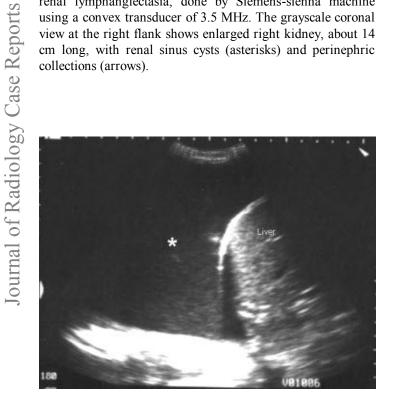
Abdomen ultrasound of a 22 male patient with renal lymphangiectasia, done by Siemens-sienna machine using a convex transducer of 3.5 MHz. The grayscale coronal oblique view at the right hypochondrial region shows massive right pleural effusion (asterisk).
